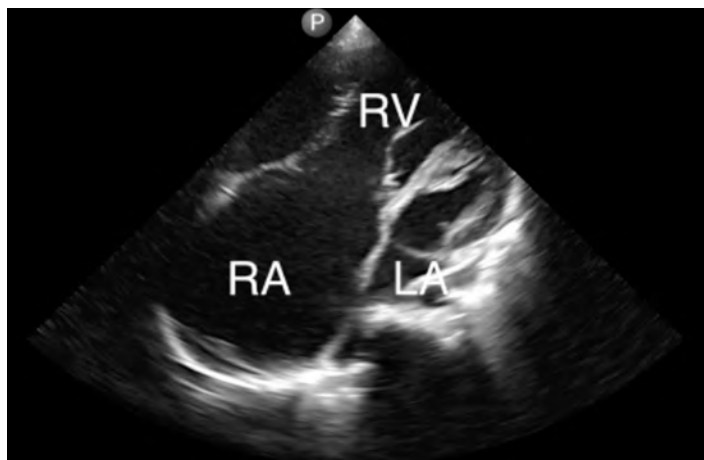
Point-of-care ultrasound apical 4-chamber view of patient with Ebstein's anomaly demonstrating the dilated right heart chambers. The left ventricle is demonstrated by the arrow. RV, right ventricle; RA, right atrium; LA, left atrium.
